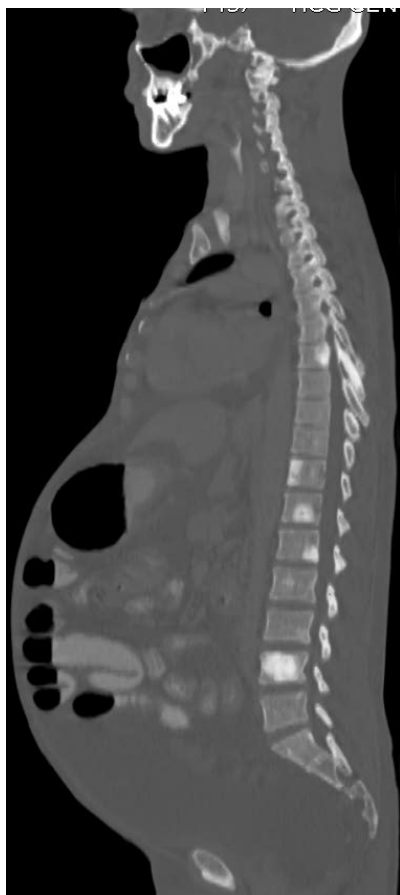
CT scan showing osteoblastic vertebral metastasis
